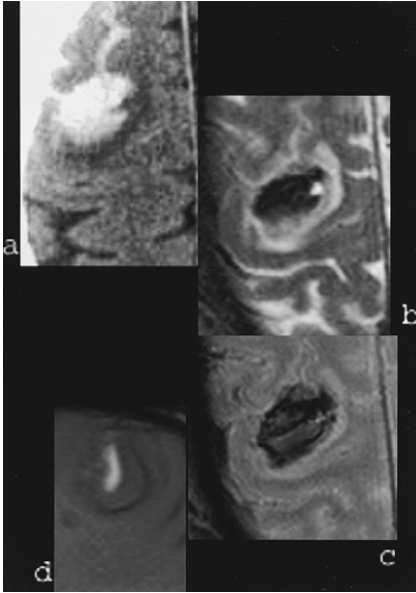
Hypertensive lobar hemorrhage. (a) Small right frontal hematoma with a small amount of subarachnoid hemorrhage on CT. (b) A T2-weighted image (T2WI) shows markedly decreased signal, reflecting deoxyhemoglobin and thus acute hematoma. (c) Note that the hematoma appears larger on the gradient-echo image because of increased susceptibility effect. A small area of increased signal on a T1-weighted image at the periphery of the hematoma is caused by methemoglobin, which is intracellular, because there is no corresponding high signal on the T2WI (d).
